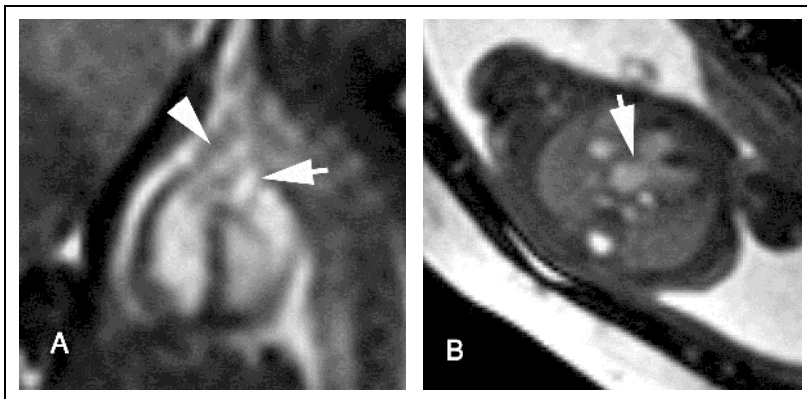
T2-SSFP CMR diagnoses outflow vessels abnormalities in-utero. (A) Sagittal MRI of 30 weeks' gestation fetus with TGA shows parallel course of Pulmonary artery (arrowhead) and aorta (arrow) at their origin (Same fetus in Fig.11A). (B) Axial MRI of 26 weeks' gestation fetus shows a single outflow tract (truncus arteriosus) (arrow) over-rides VSD
